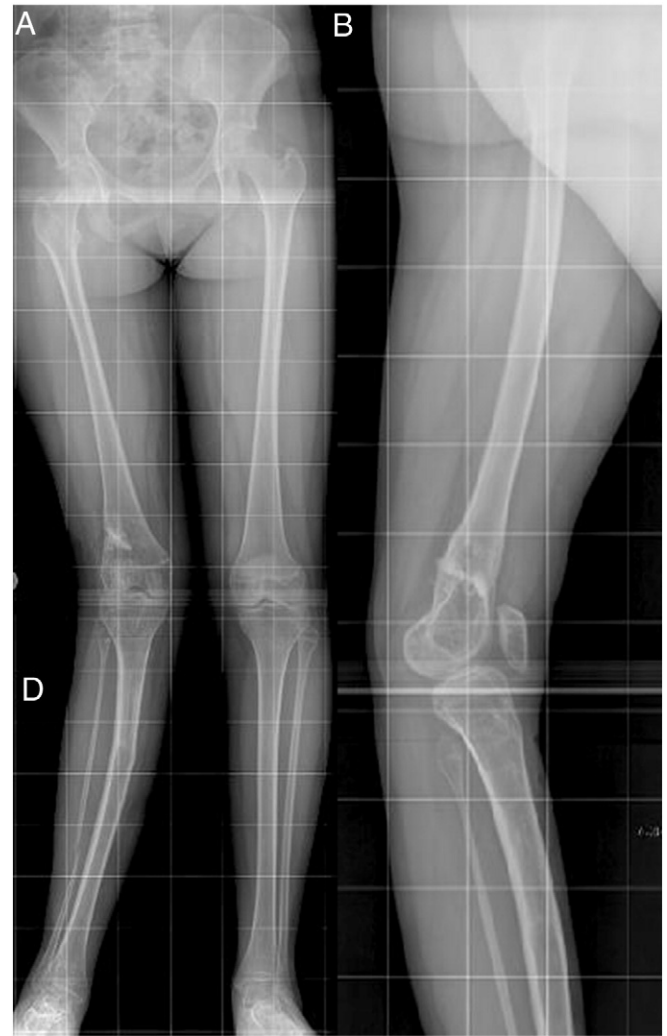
A. Preoperative full length radiograph which demonstrates genu valgum of 24° . B. Preoperative lateral projection of right lower limb showing 24° of recurvatum.
